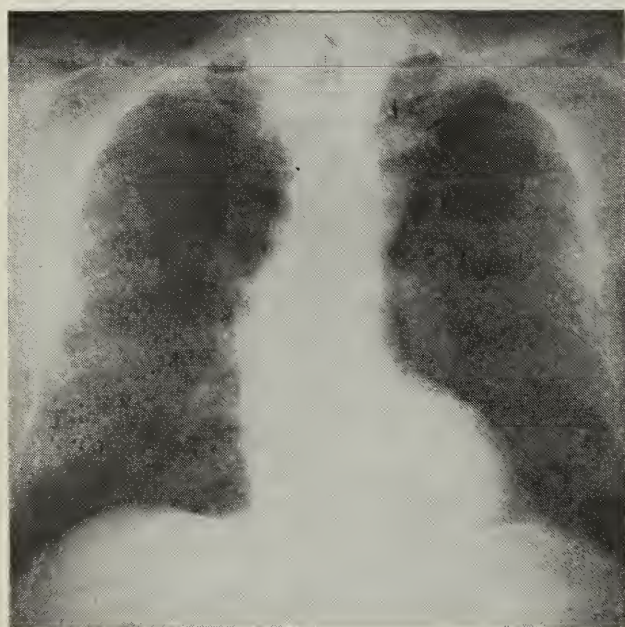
The arrows surround the density observed on a routine PA chest x-ray. This density is immediately adjacent to the aortic knob.
